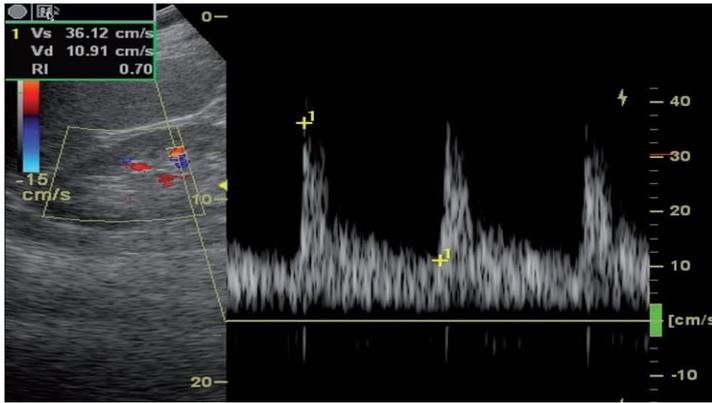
b Colour Doppler is use to identify the interlobar vessels from which a spectral trace is captured. Peak systolic and end diastolic measurements are recorded by placing the measurement calliper at the relevant position within the cardiac cycle.
